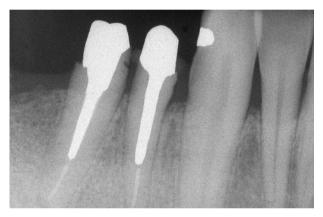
A radiograph taken after post and core fabrication and insertion into the mandibular premolars demonstrates the relationship of the planned restorative margins to the alveolar crests.
